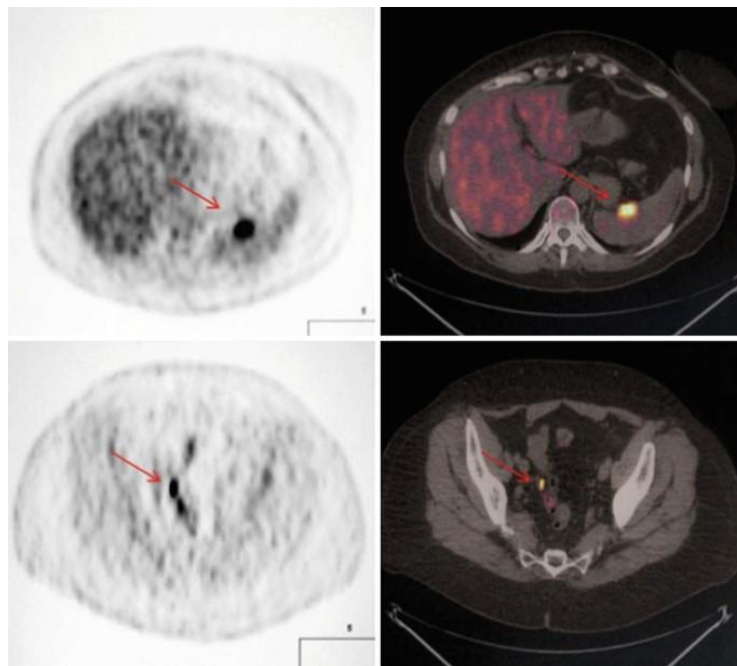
52-year-old woman with a history of bilateral ovarian carcinoma presenting with slight but persistent elevation of tumor marker serum levels and negative findings on MRI imaging. ^{18}F FDG-PET/CT revealed two ^{18}F FDG avid lesions in the peritoneum [15]
